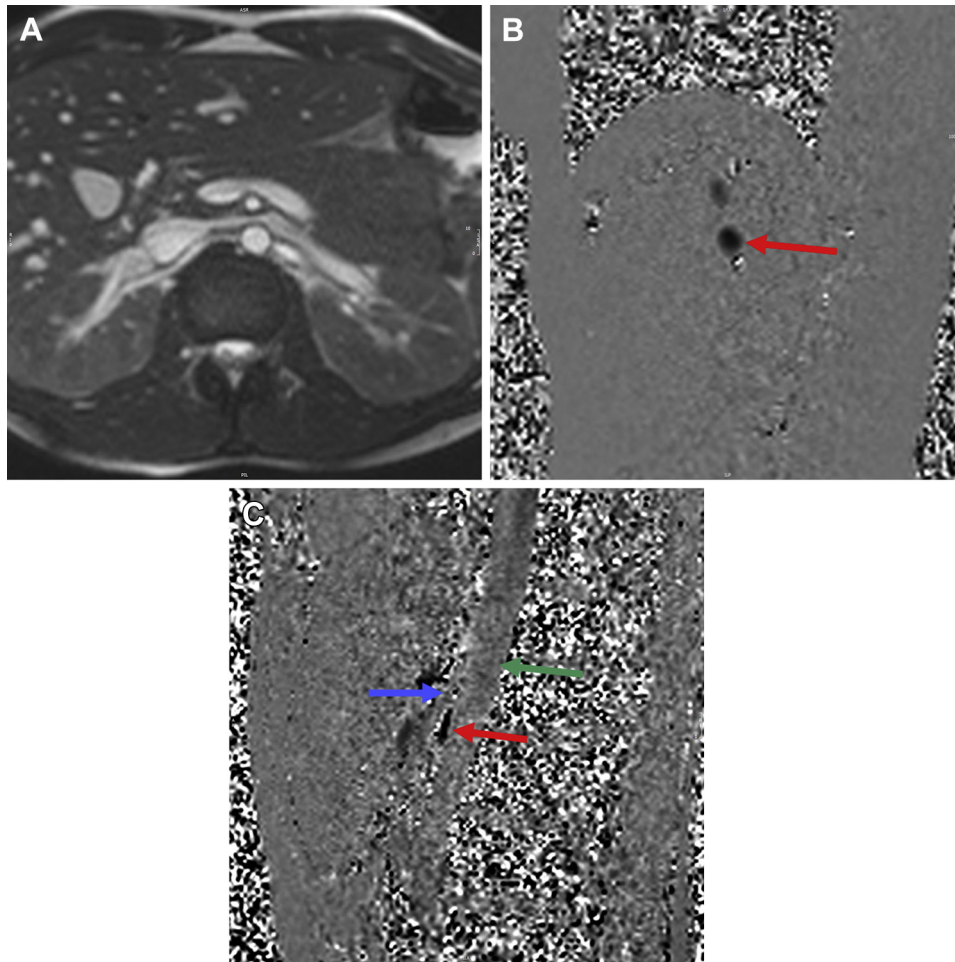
A, Axial two-dimensional bright-blood images demonstrate compression of the left renal vein (LRV) by the superior mesenteric artery (SMA). Cross-section phase-contrast magnetic resonance images (PC-MRI) of the (B) peripheral and (C) central LRV images (*red arrows*) demonstrate a minimum diameter decrease from 1.5 cm to 0.5 cm in the central LRV compared with the peripheral LRV. The *green arrow* indicates the aorta, and the *blue arrow* indicates the SMA.
